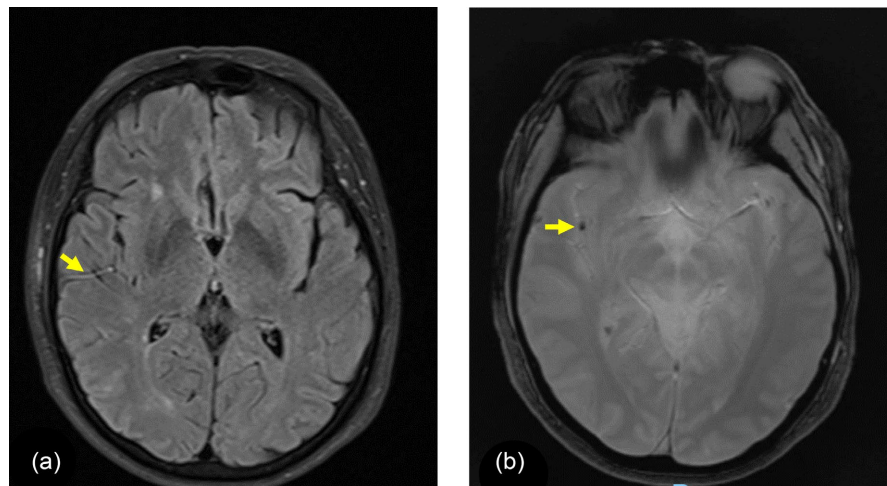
Axial brain MRI performed 1 hour after symptom onset. (a) FLAIR sequence shows a linear hyperintensity along the right fronto-opercular cortical artery (yellow arrow), consistent with a vascular hyperintensity due to slow or stagnant flow in the M3 segment territory of the middle cerebral artery. No parenchymal FLAIR signal abnormality is detected at this stage; (b) Corresponding axial T2* gradient-echo sequence demonstrates a focal, well-defined hypointense signal (yellow arrow) located at the right M1-M2 junction, indicating the presence of acute intraluminal thrombus.
